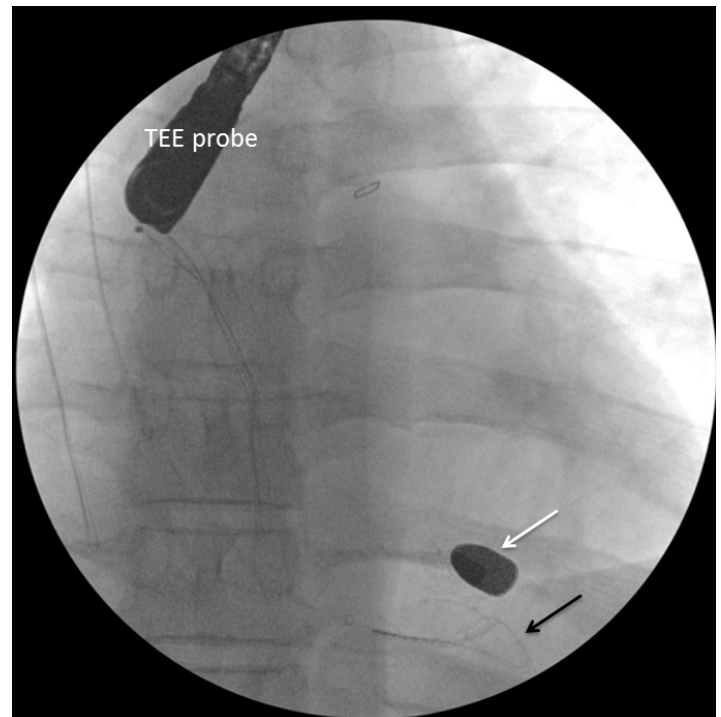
Fluoroscopy intraoperatively showing snare (black arrow) next to bullet (white arrow) and transesophageal echocardiogram probe.
